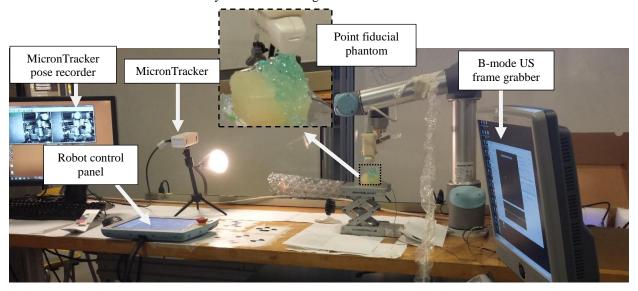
Freehand ultrasound calibration setup
